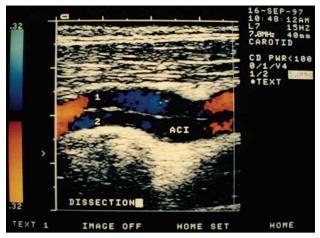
Extracranial ultrasound color Doppler flow imaging showing dissection of the internal carotid artery. ACI – arteria carotis interna.
